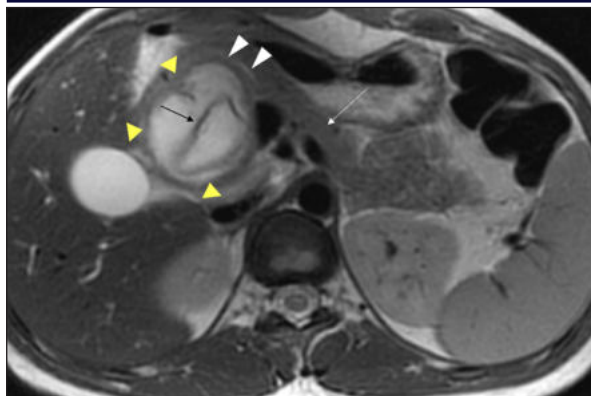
T2 weighted Axial MRI image showing Irregular thick walled cystic lesion (yellow arrowheads) noted in the region of the head and uncinate process of pancreas. A laminated irregular floating membrane is seen within (black arrow). Main pancreatic duct in the head of the pancreas is prominent (white arrowheads). The body of the pancreas is seen (white arrow).
